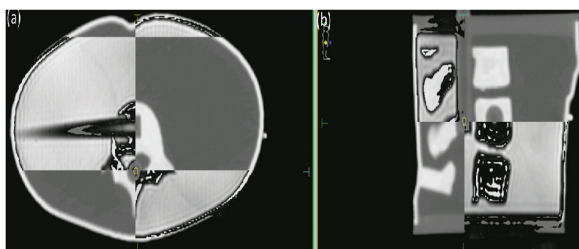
Pretreatment setup displays for Varian TrueBeam delivery. (a) BrainLab ExacTrac. (b) Verification by cone beam computed tomography.
